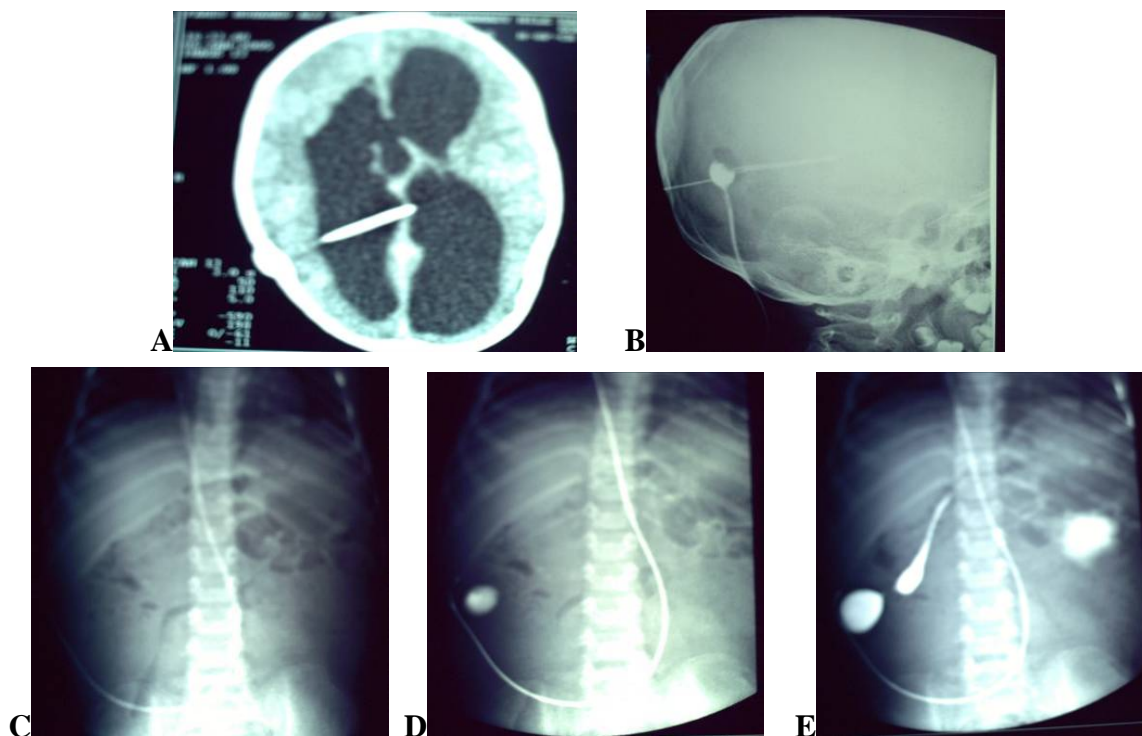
Case: 3 male patient 6 years old, note that CT brain showed dilated ventricles, radiographic shuntogram revealed that there was localized peritoneal collection of contrast material denoting distal obstruction due to peritoneal adhesion and CSF was easily aspirated from reservoir
